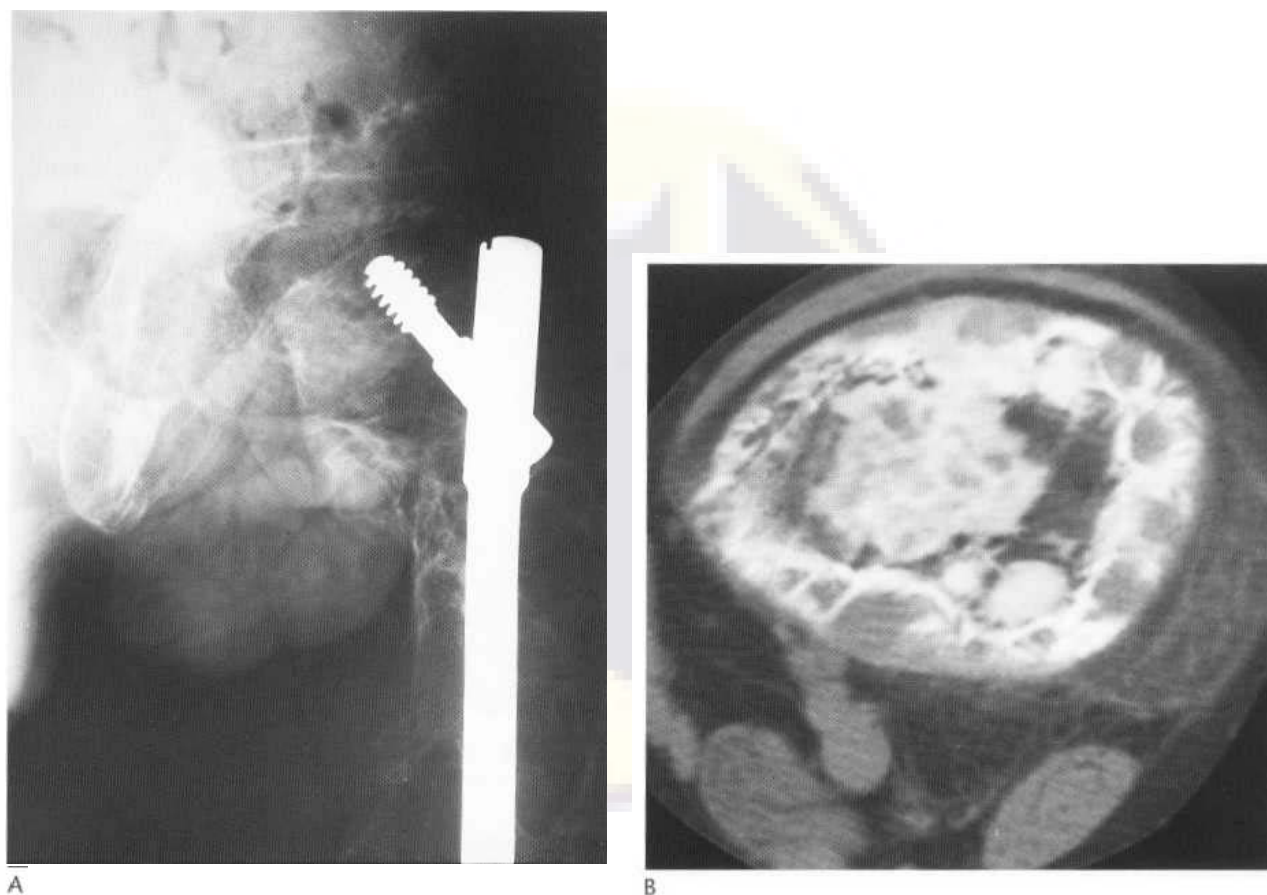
Fibrous dysplasia. (A) The plain film in this much more severe polycystic case shows marked enlargement and deformity of the pelvis and proximal femur. There is marked bony expansion with extensive cyst formation. The shepherd's crook deformity has been stabilised. (B) The CT scan shows the mixed pattern of tissues seen in fibrous dysplasia, ranging from cystic through ground-glass to heavily mineralised tissue.
